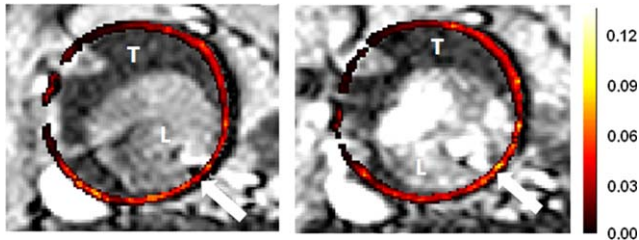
T1w MR images with K^{trans} maps overlay from one patient (maximal diameter of 53 mm). Images were acquired 1 week apart. White arrows indicate the vessel wall with K^{trans} map overlay (T = thrombus, L = lumen). The generated K^{trans} maps color scale (dark red represents low K^{trans} value) and the K^{trans} distribution for the two examinations are similar, but with a little mismatch in anatomic location between the first and second MRI scan which was unavoidable. [Color figure can be viewed in the online issue, which is available at wileyonlinelibrary.com.]
